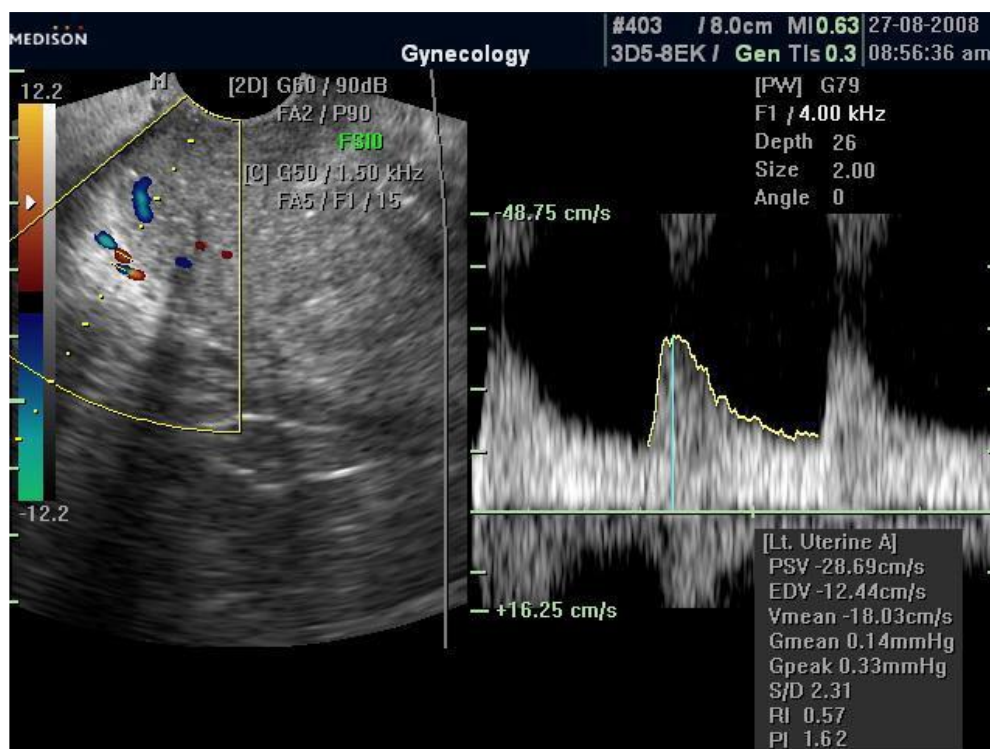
Doppler parameters of the Lt. uterine artery in endometrial carcinoma (*RI 0.57, PI 1.62*) (*Alcazar et al., 2003*)
